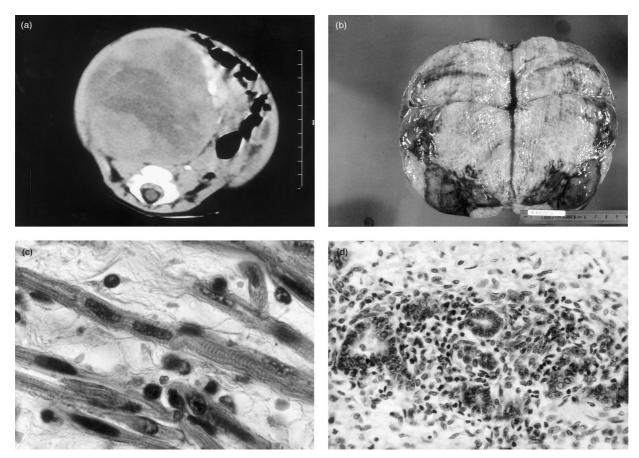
(a) Computed tomographic scan of the abdomen revealing a large well-demarcated tumour in the right kidney. (b) Primary tumour shown on cut section, replacing most of the kidney and of variegated appearance. The white areas were necrotic. (c) The tumour was constituted almost exclusively of striated muscle cells in a myxoid background. (H & E,×1500) (d) Rare foci of blastema with tubules were present, allowing the diagnosis of nephroblastoma. (H & E,×610).
